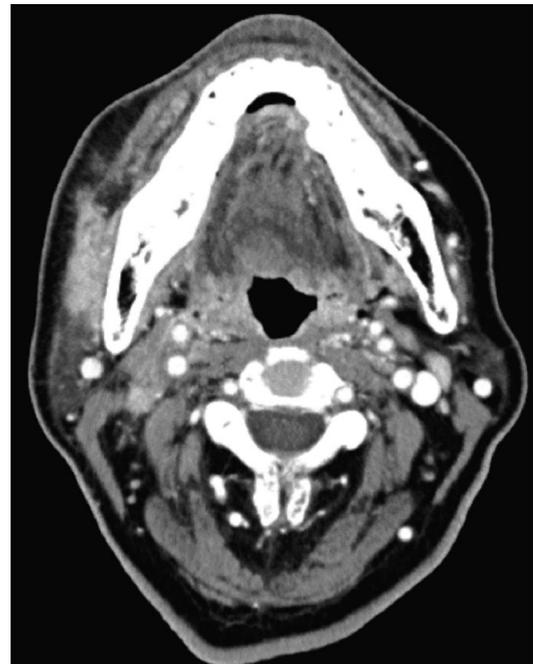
Contrast-enhanced CT view after 21 days of antibiotic and anticoagulant administration. Decreased size of the right IJV with remaining prominent wall enhancement and an internal filling defect: chronic changed thrombophlebitis.
